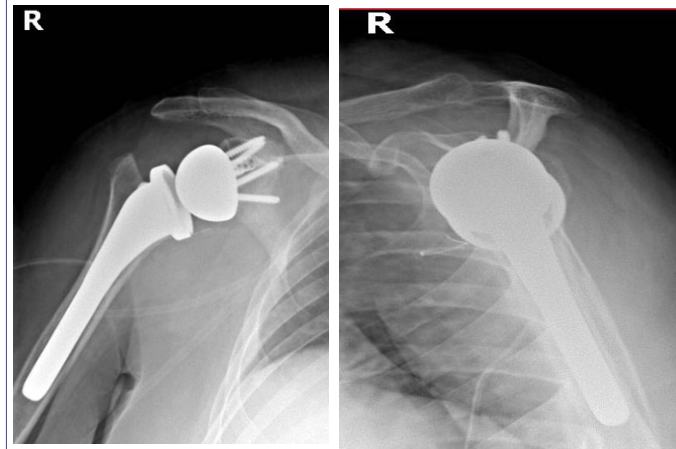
Postoperative Xray. A, AP view, and B, P View
